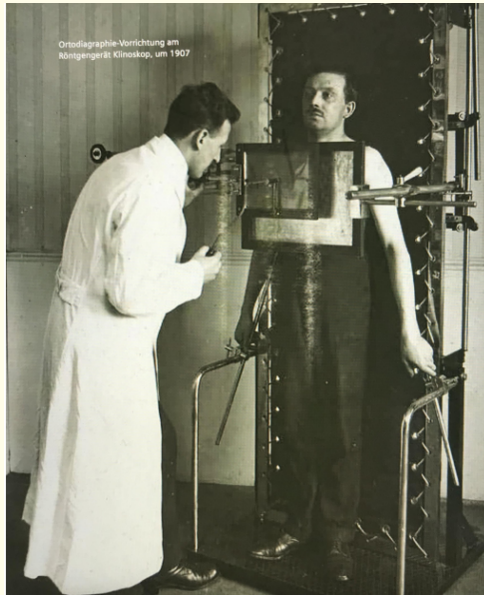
Roentgenography about 1907.
